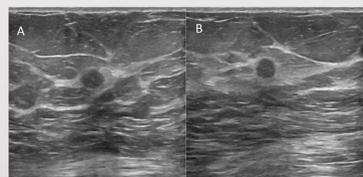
Right Breast Mass Ultrasound Correlate. Radial (A) and anti-radial (B) sonographic images at 2:00, 7cm from nipple demonstrate a round, circumscribed, parallel, hypoechoic 0.6 cm mass with mild posterior shadowing and surrounding architectural distortion. Subsequent biopsy results were consistent with invasive ductal carcinoma.
